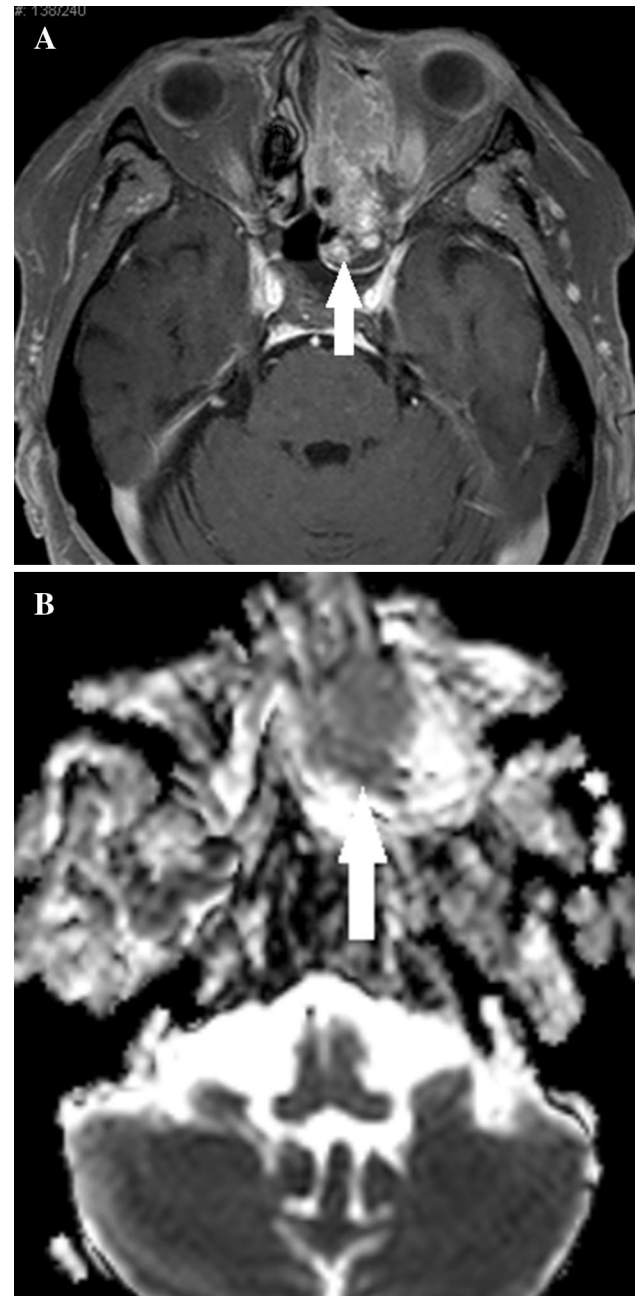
(a) Postgadolinium T1-weighted image of a 52-year-old male shows an ill-defined enhancing mass involving the left nasal cavity (*arrow*). (b) The low signal observed in the corresponding ADC map is indicative low ADC values in the mass, suggestive of a highly cellular process, for example a malignancy. This proved to be sinonasal undifferentiated carcinoma (SNUC)
